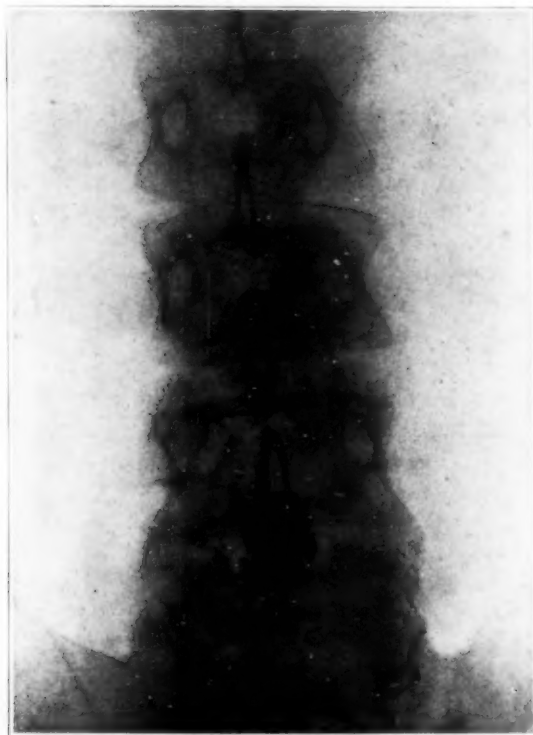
(case E. H.).—Roentgenogram of iodized oil arrested at the fifth lumbar vertebra in a case of extradural chondroma below that level.
